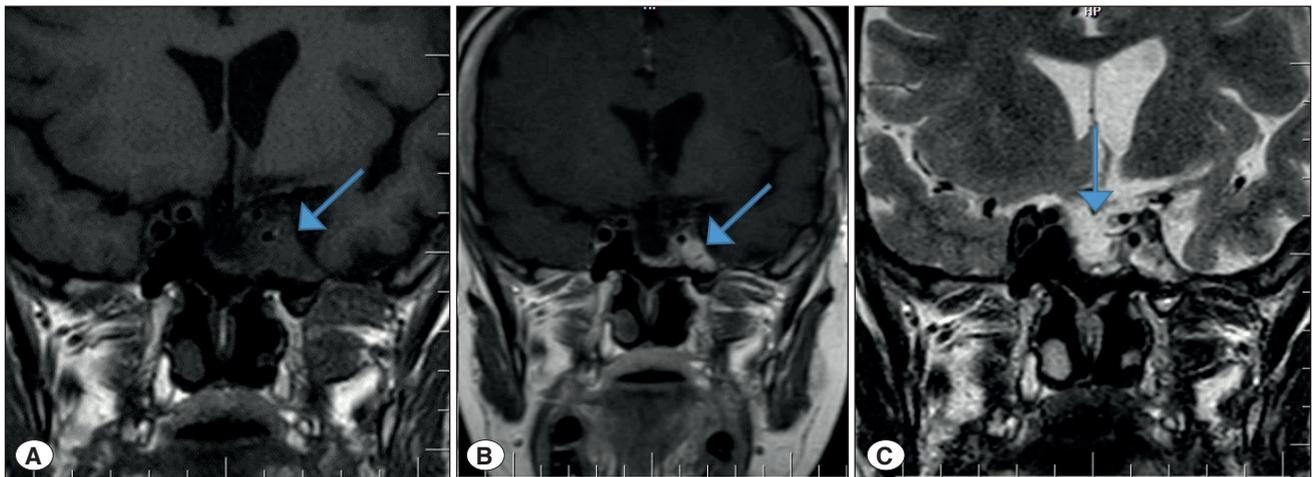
A) MRI image (T1-weighted 21x17x15mm heterogeneous contrast enhancing mass, diffusely surrounding the left optic nerve and filling the left ICA cavernous segment which is considered to be recurrence/residue. B) MRI image (T1-contrast enhanced heterogeneous contrast enhancement in the mass. C) MRI image (T2-weighted Empty sella in the right part of the pituitary gland.
